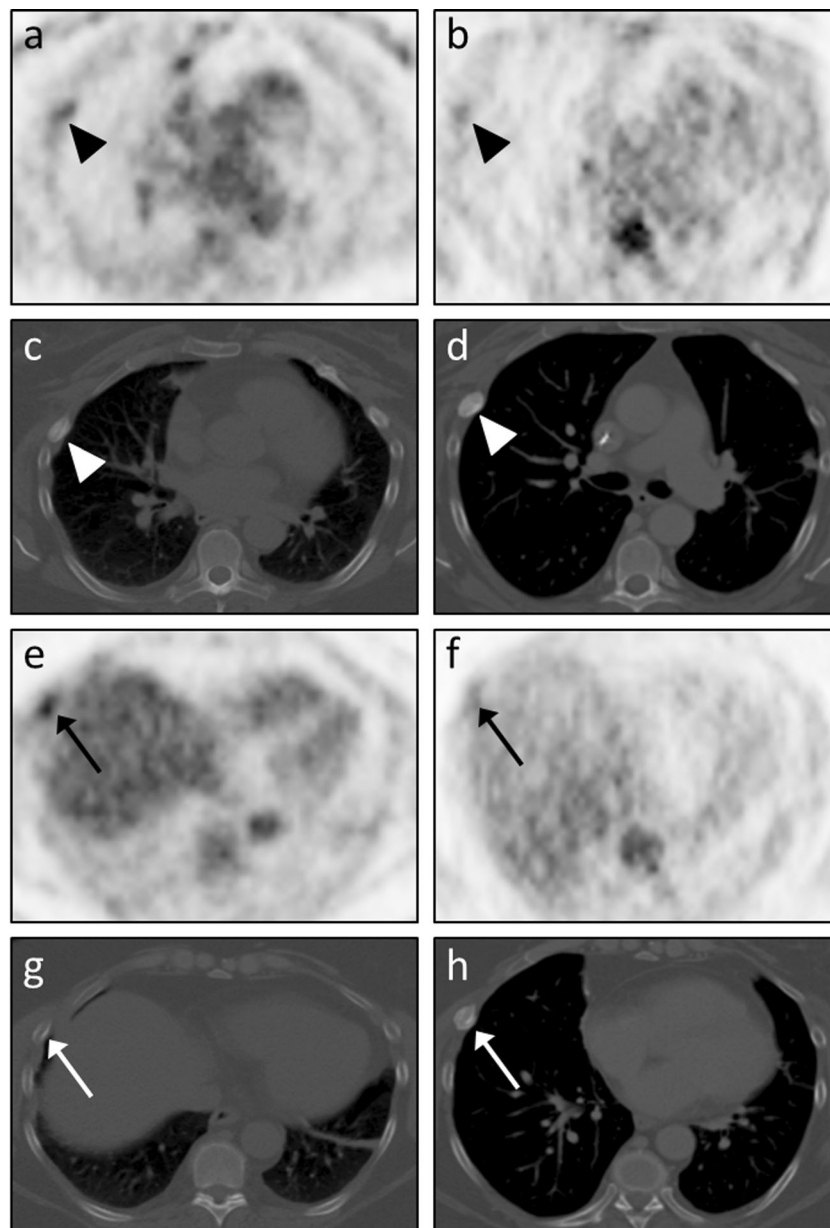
Tracer washout from indeterminate rib FFBLs. Reader A remarked that only 2 of the 50 FFBLs were not well-visualized on the PET images from the PET/MRI dataset. Both lesions were from the same patient, a 53-year-old woman with metastatic osteosarcoma, and were found in the right 4th (arrowheads in a–d) and right 6th (arrows in e–h) ribs. Both readers judged visual conspicuity of the right 4th rib FFBL to be greater on PET images from the PET/CT dataset (a) than on PET images from the PET/MRI dataset (b). Transaxial CT images from the PET/CT dataset (c) showed a sclerotic osseous focus with somewhat ill-defined margins corresponding to this FFBL. A chest CT performed 3 months later (d) again showed an osseous focus with increasing sclerosis and more well-defined margins. Similarly, both readers judged visual conspicuity of the right 6th rib FFBL to be greater on PET images from the PET/CT dataset (e) than on PET images from the PET/MRI
